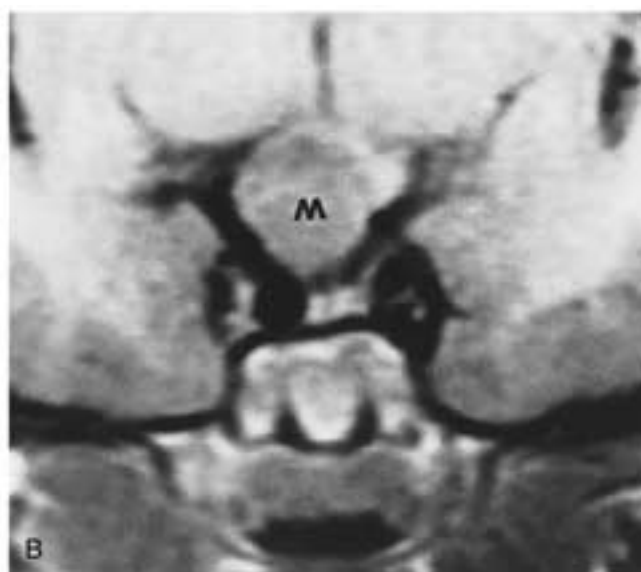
Recurrent retinoblastoma. A, Axial PW MR image shows a right false eye and marked tumor along the right optic nerve (*curved arrow*). Note the normal left optic nerve (*arrow*) and the tumor mass (*M*) in the sellar region. B, Coronal PW MR image shows a marked tumor mass (*M*) in the sellar and suprasellar region.
